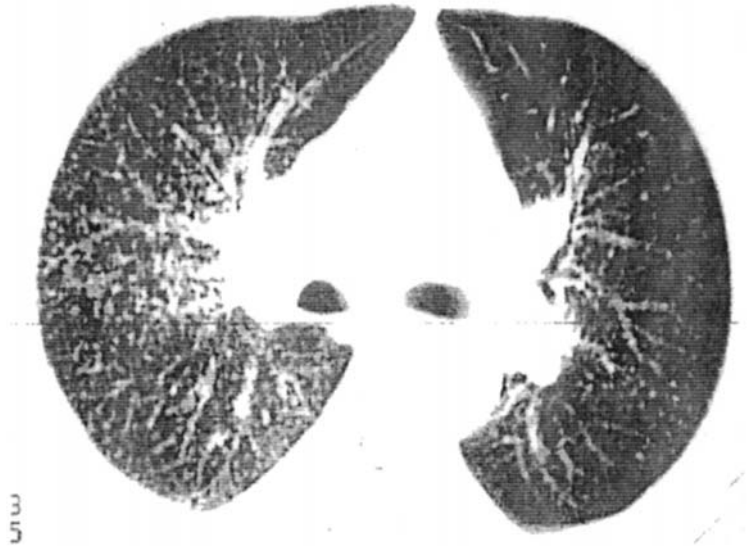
Pulmonary sarcoidosis. HRCT scan at the level of the carina demonstrates innumerable nodules; the distribution along bronchi gives some of the bronchi a “beaded” appearance.
